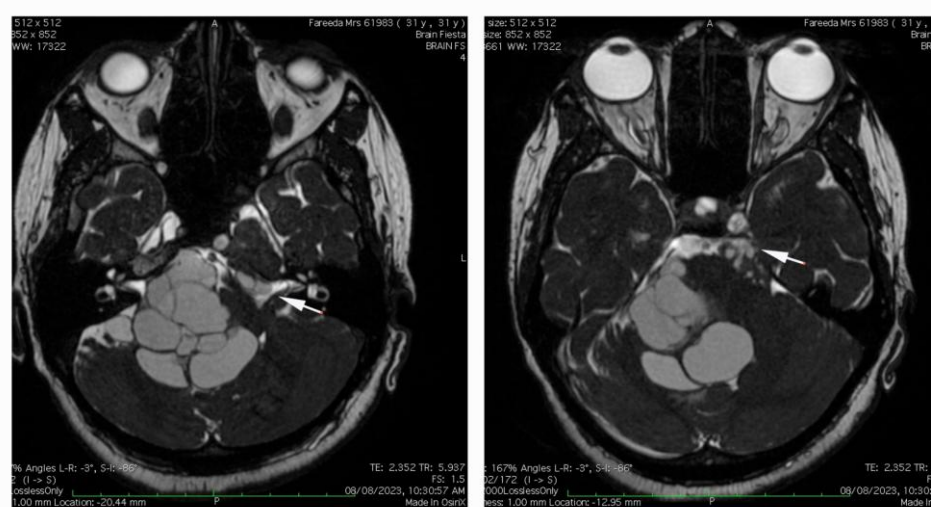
MRI brain showing small solid cum cystic mass in left prepontine cistern with infiltration into left Meckel's cave
